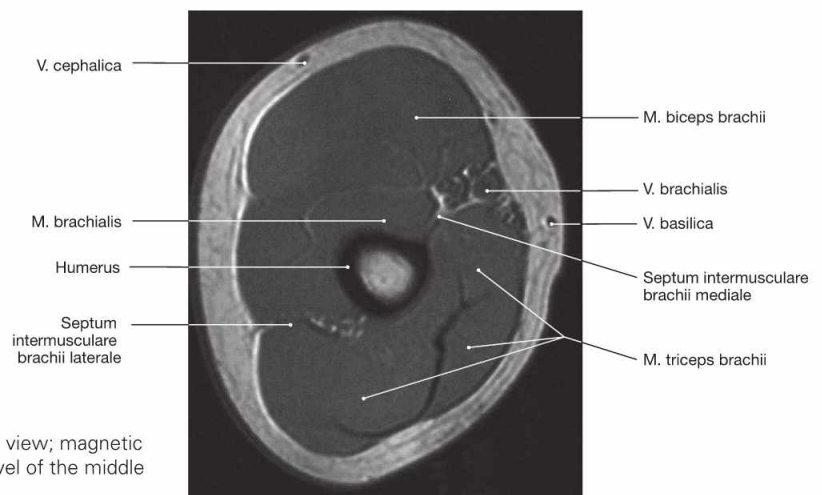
Upper arm, Brachium, right side; distal view; magnetic resonance imaging cross-section (axial MRI) at the level of the middle part of the upper arm.
